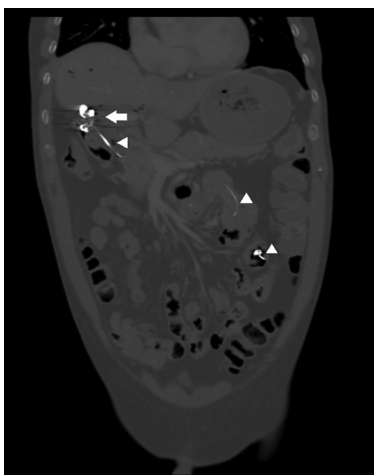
Coronal computed tomography image demonstrates coils in the pseudoaneurysm sac (arrow) with multiple metallic objects in the common bile duct and the small bowel loops consistent with the migrated coils (arrowhead)
